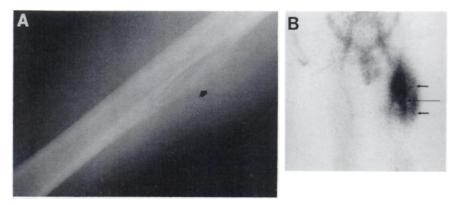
(A) X-ray of left femur showing lytic cortical lesion and ill defined periosteal reaction of the proximal and lateral aspect of the diaphysis of the femur consistent with osteomyelitis with overlying soft-tissue swelling. (B) Early ¹¹¹In-IgG scan shows intense uptake in the soft tissues (short arrows) and longitudinally in the topography of the left femur (low arrow).
